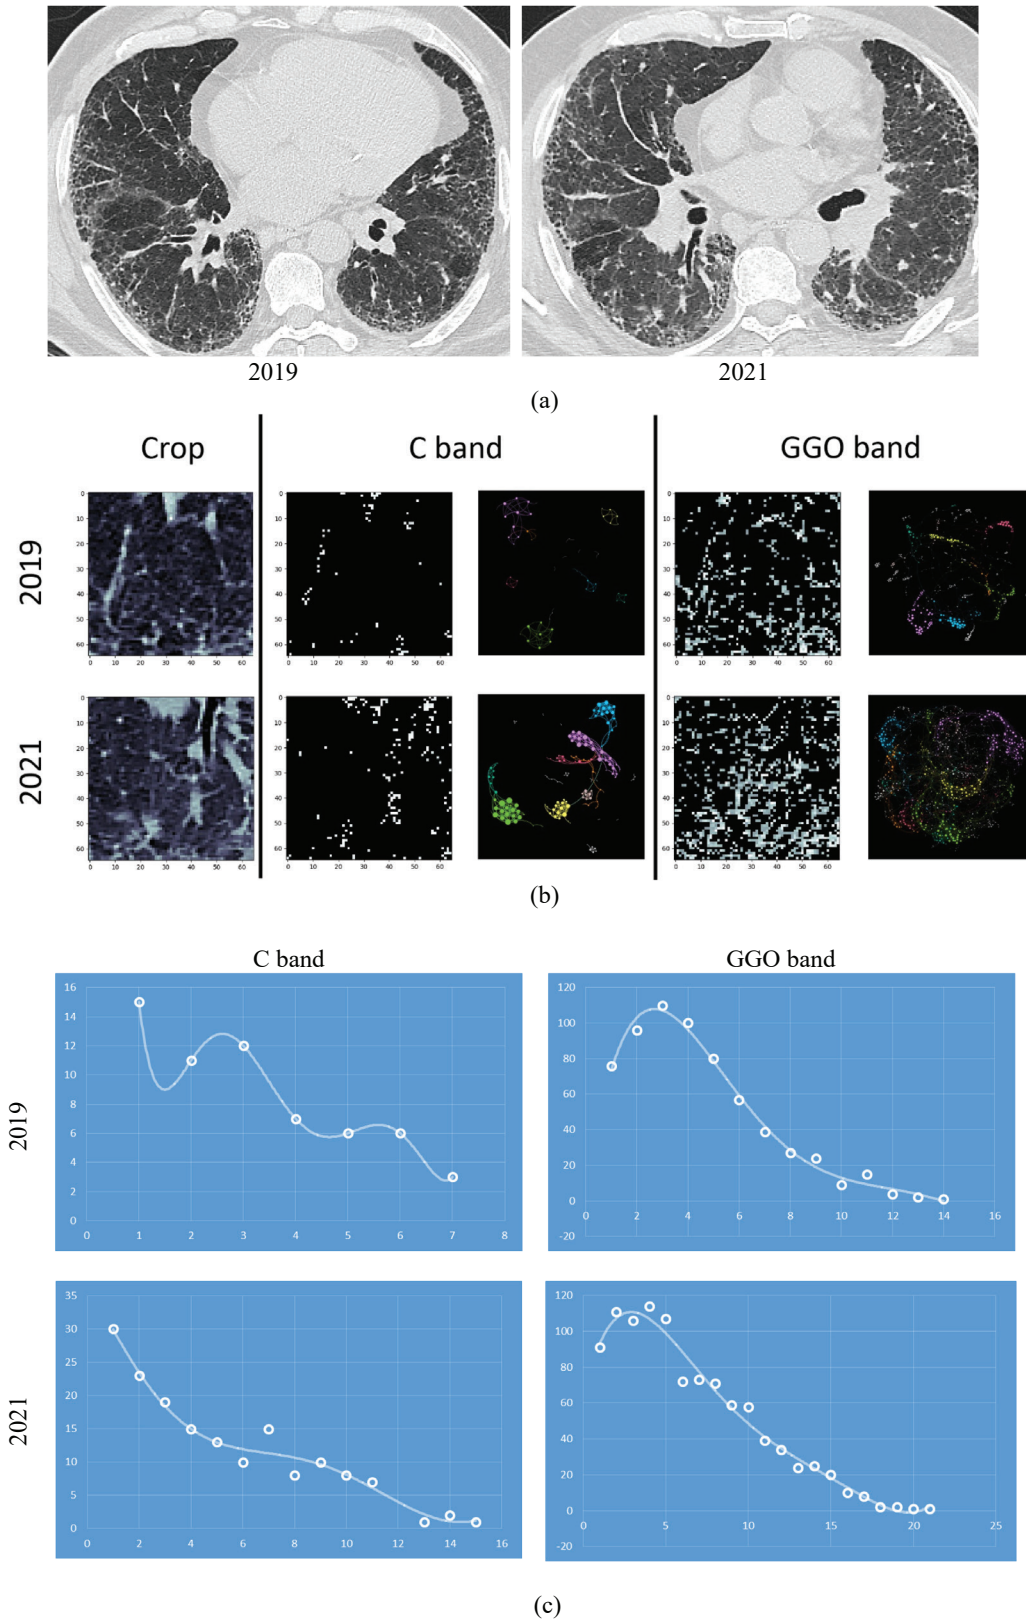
IPF patient – larger time gap (2 years). (a) relevant basal axial HRCT slices (b) Significant changes on the C and GGO bands (c) Degree distribution (lesion intensity) for the C and GGO bands.
